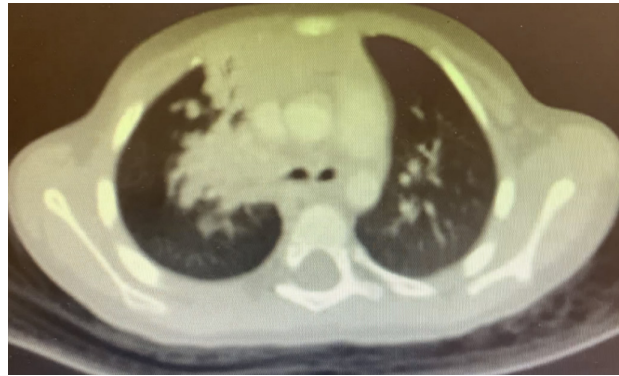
CT scan showing diffuse consolidation and bronchiectasis of the right upper lobe due to severe bronchomalacia
